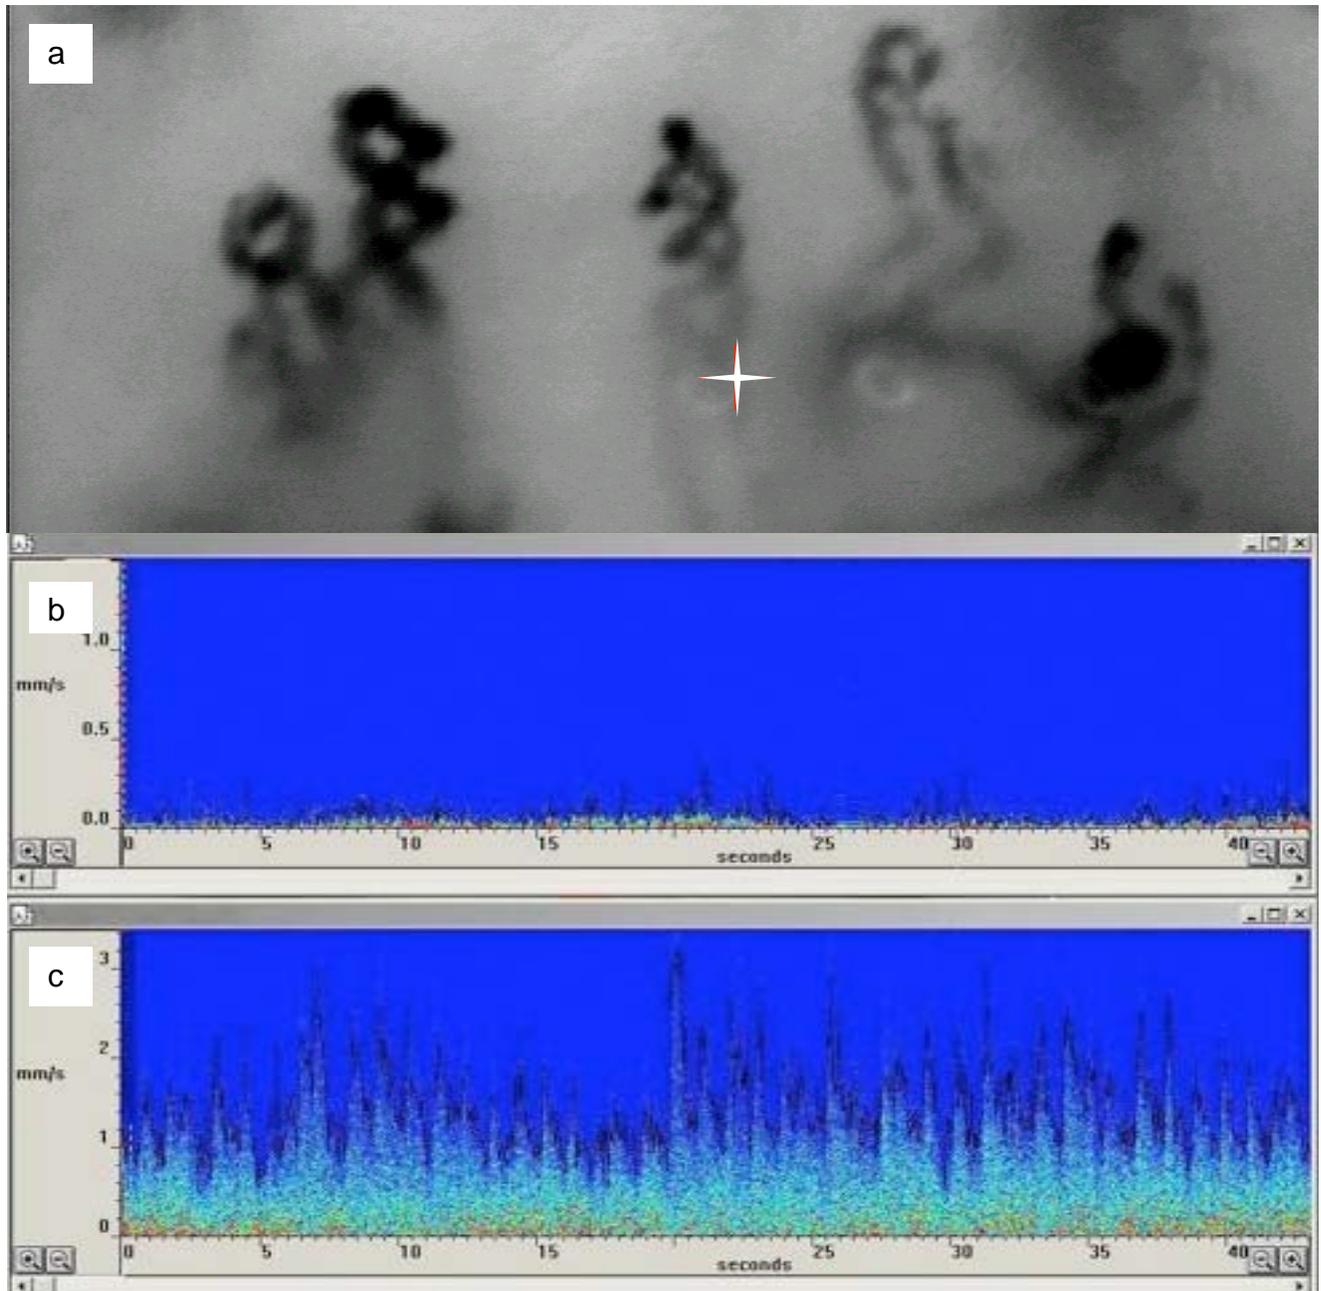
Nailfold capillaries in 250-fold magnification (a): + indicates focus of laser Doppler. Laser Doppler flow after treatment with placebo (b) and sildenafil (c) in a capillary of normal shape and width (not shown) in the same patient.
